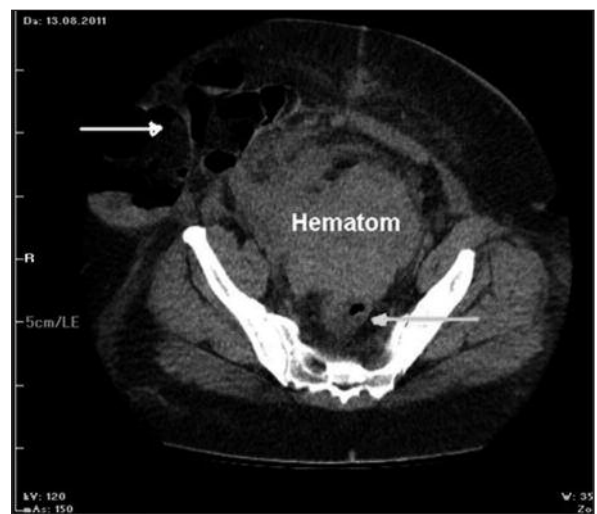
Obstruction of the sigmoid colon and rectum due to pelvic hematoma (grey arrow) and incisional hernia (white arrow). Imagine of non-contrast CT.
